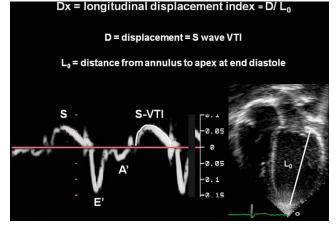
Method of measurement of longitudinal mitral annular systolic displacement index from DTI. A', tissue Doppler late diastolic wave; D, displacement; E', tissue Doppler early diastolic wave;  $L_0$ , distance from mitral valve annulus to LV apex at enddiastole; *S*-wave VTI, VTI of tissue Doppler systolic S wave.
